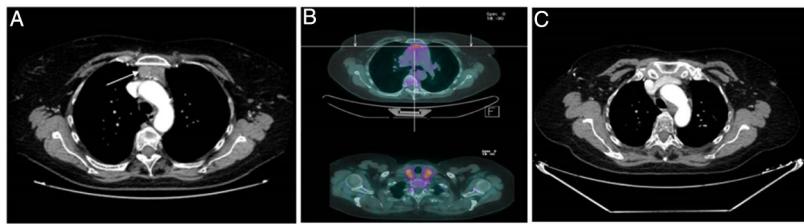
CT and PET-CT thymoma images.
